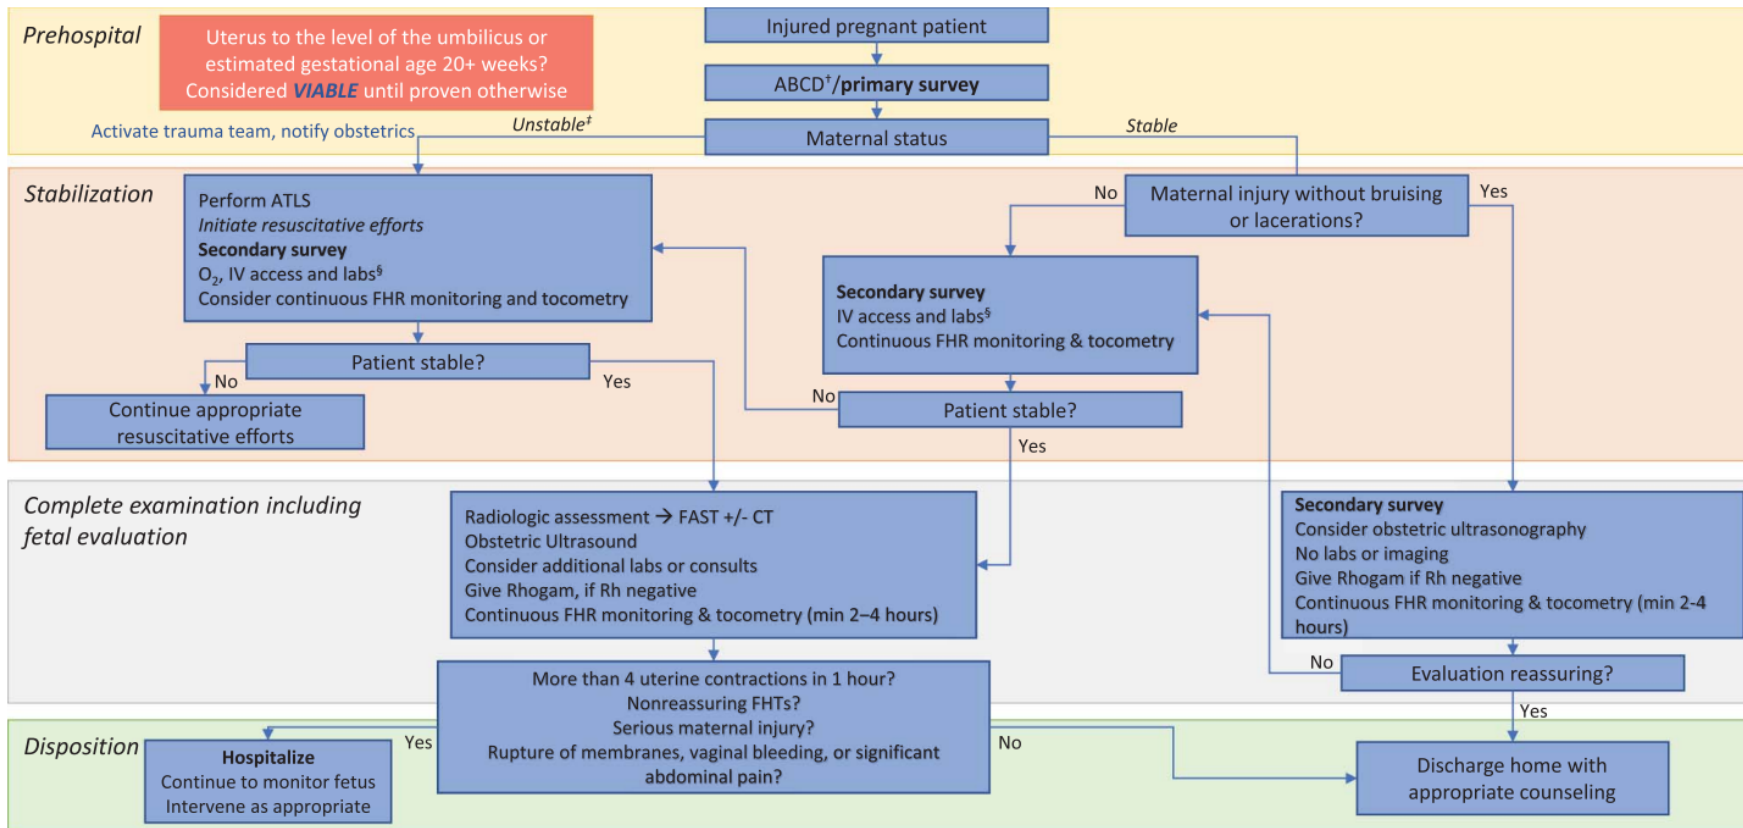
Evaluation and management of trauma in pregnancy in viable* gestations. *Viable defined as 22–24 weeks of gestation; varies by region. [†]ABCD: airway, breathing, circulation, displacement (ensure left lateral tilt of patient). [‡]Unstable: cardiac arrest, unresponsive, loss of airway or respiratory arrest, blood pressure less than 80/40 or heart rate less than 50 or greater than 140 beats per minute (bpm), viable fetus with fetal heart rate (FHR) less than 110 or greater than 160 bpm. [§]Laboratory values: if unstable: complete blood count, coagulation profile, fibrinogen, fetal maternal hemorrhage screen, type and screen, creatinine±arterial blood gas; if stable: complete blood count, coagulation profile, fibrinogen, fetal maternal hemorrhage screen, type and screen. ATLS, *Advanced Trauma Life Support*; IV, intravenous; FAST, focused abdominal sonography for trauma; CT, computed tomography; FHT, fetal heart tone.
